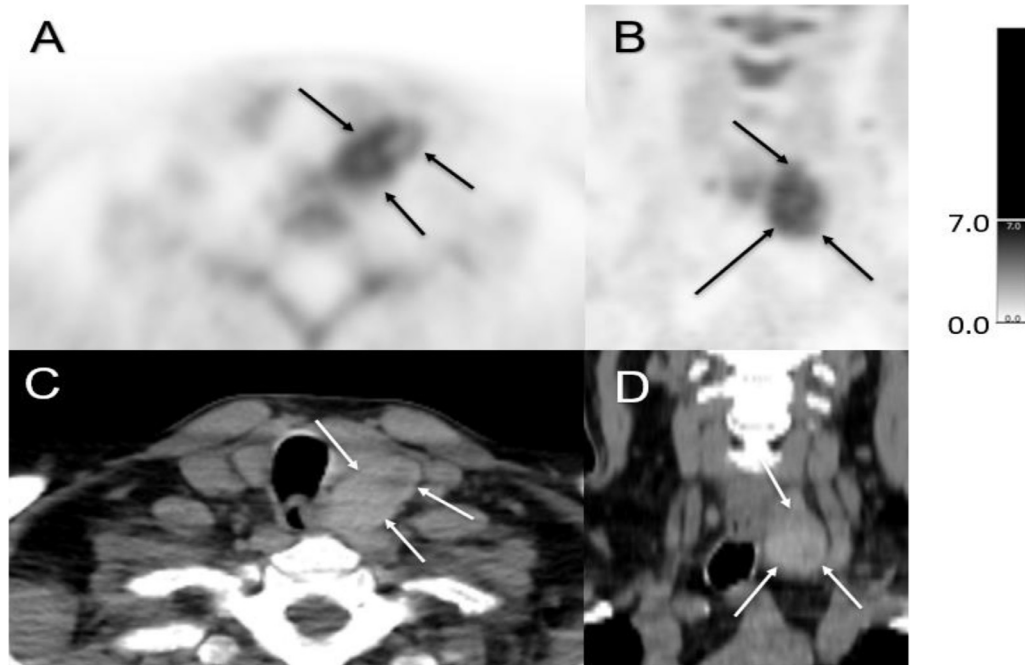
(A) Axial $[^{11}\text{C}]$ C-Methionine PET, (B) coronal $[^{11}\text{C}]$ C-Methionine PET, (C) axial noncontrast CT and (D) coronal noncontrast CT images demonstrate inhomogeneous, and in some areas, intense methionine uptake. The uptake corresponds to a larger process located posterior to the left thyroid lobe, extending caudally and toward the esophagus (position 2-5) [12]. These findings are indicative of a large, partially cystic transformed parathyroid adenoma, suggesting its probable diagnosis.
